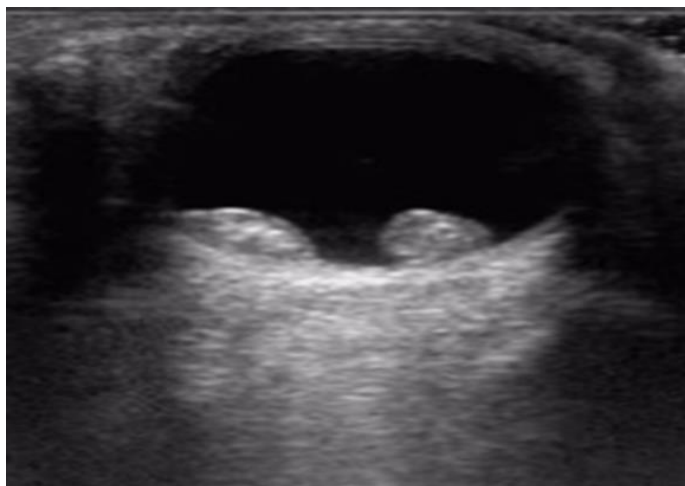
Fragments of sonogram of a 42-year-old patient
